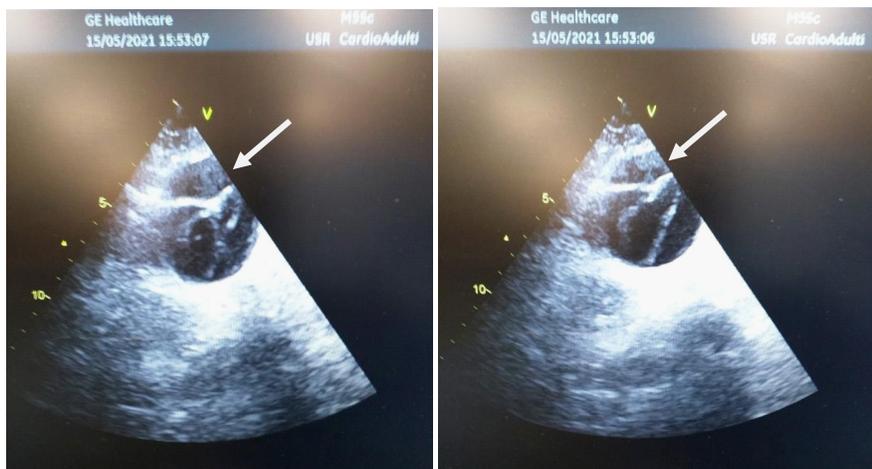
Echocardiography: aortic bulb dilation - Ascending aorta with double track appearance.
